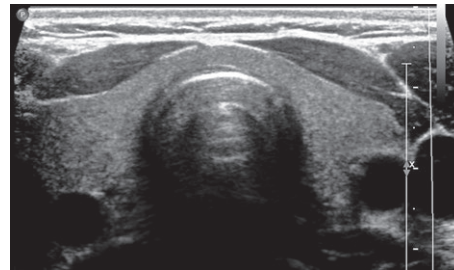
Normal thyroid gland. Transverse ultrasound through the neck shows that the normal thyroid consists of two lobes and a bridging isthmus with a homogenous appearance on ultrasound.
